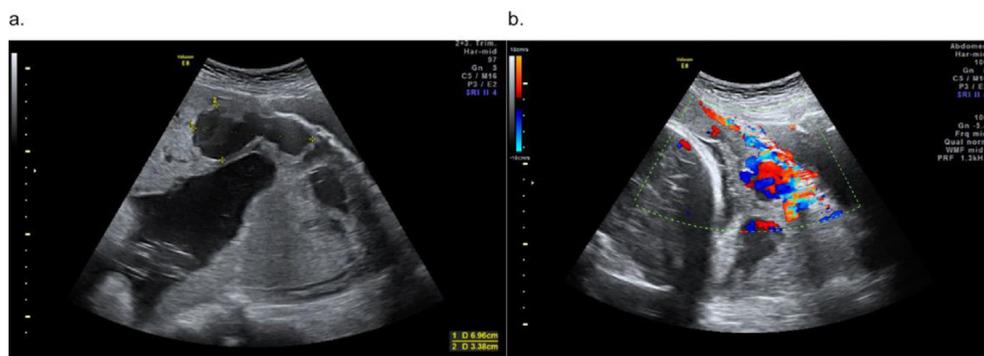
The characteristic ultrasound images in morbidly adherent placenta. (A) The placenta adhering to the anterior and posterior uterine walls in ultrasound with color Doppler. (B) Hypervascularization surrounding the uterine anterior wall and placenta in color Doppler. In these situations, we perform further MRI scans to evaluate the area and depth of MAP.
